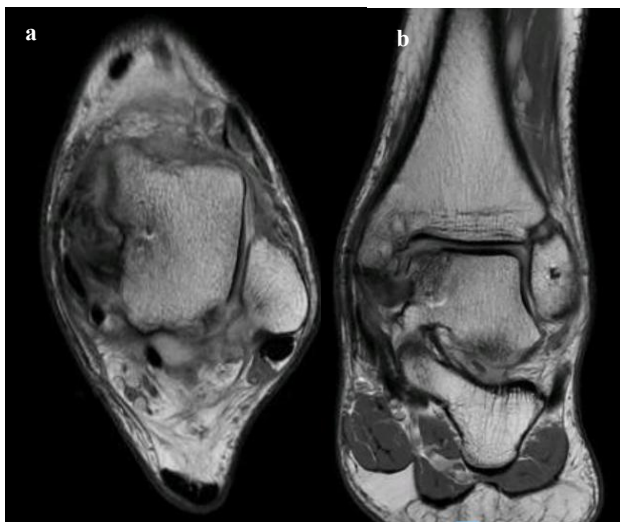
(a and b): Post-operative axial and coronal T1-weighted MRI images demonstrating the Broström-type lateral ligament repair anchor site with complete absence of the excised AFCM.
